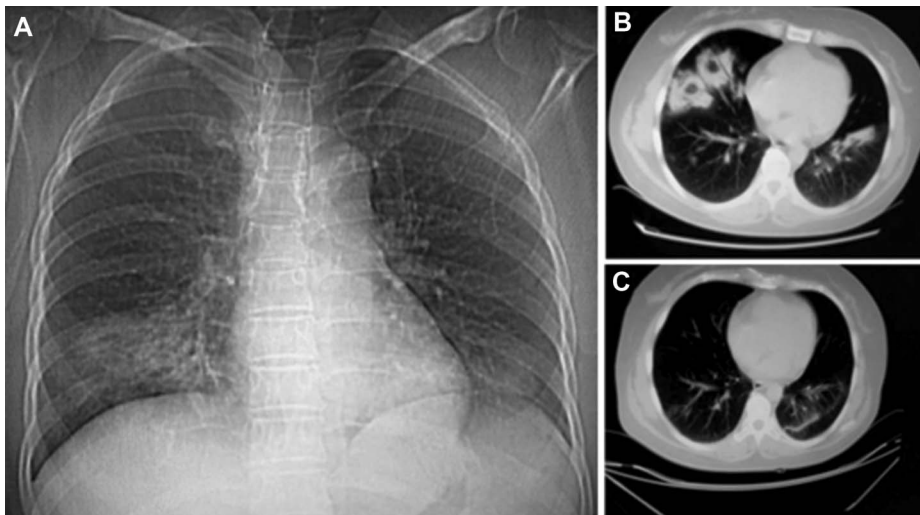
A, The chest x-ray on July 11, 2011, showed the inflammation change in lower left lung. B, A CT examination on July 11, 2011, revealed multiple divergent exudative lesions in the right, middle and lower lobes of the lungs, and the divergent exudative lesions resembled clumps of cotton balls. Some patchy shadows were also observed. C, On the last CT, that is, November 28, 2011, each lesion was obviously absorbed. In the ligule left lung segment and lower lobe in both lungs, the patchy inflammation showed some change.
